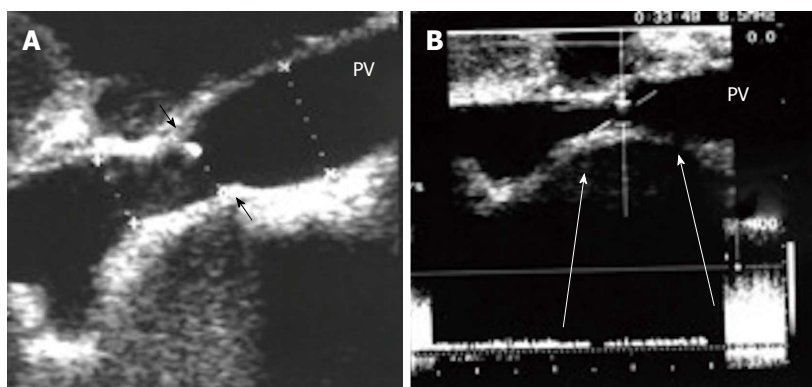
Intra-operative portal vein stenosis. A: B-mode US image showing PV anastomotic stricture; the suture line is seen encroaching on the lumen (arrows) with high level echoes seen at the site of anastomosis, representing turbulence of flow; B: Pulsed Doppler image demonstrating anastomotic elevation of the PV velocity (6-fold) compared to the pre-anastomotic velocity. The pressure gradient across the anastomosis was 8 mmHg, indicating the need for surgical anastomotic revision. PV: Portal vein.
